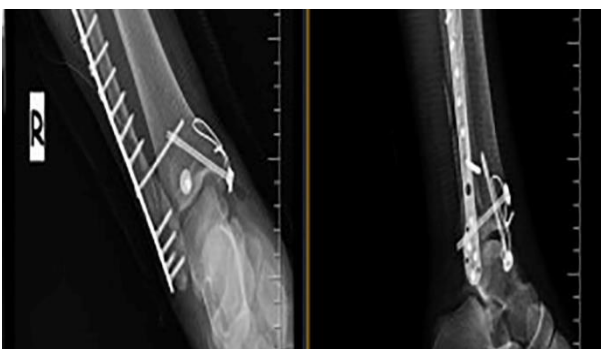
Malleolus screw or cortical screw was used as fixation material radiography
